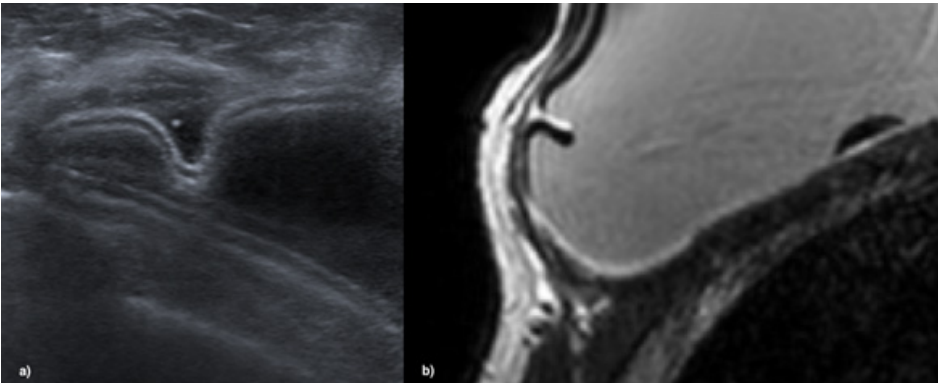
Ultrasound (a) and MRI (b) showing the presence of a radiating fold.
